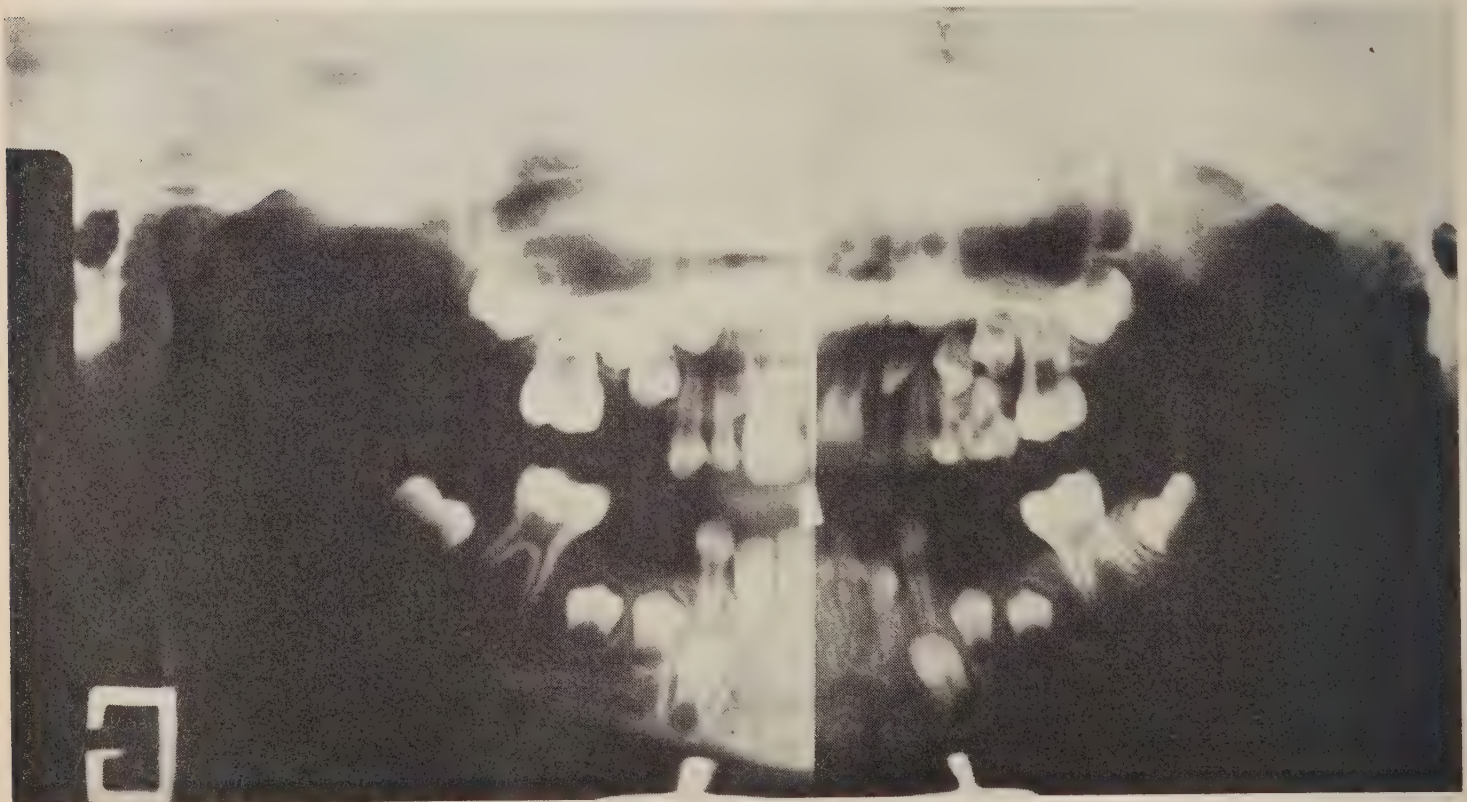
Panoramic radiograph of a six year old girl demonstrating the premature extraction of the lower primary molars and upper left primary molars.
